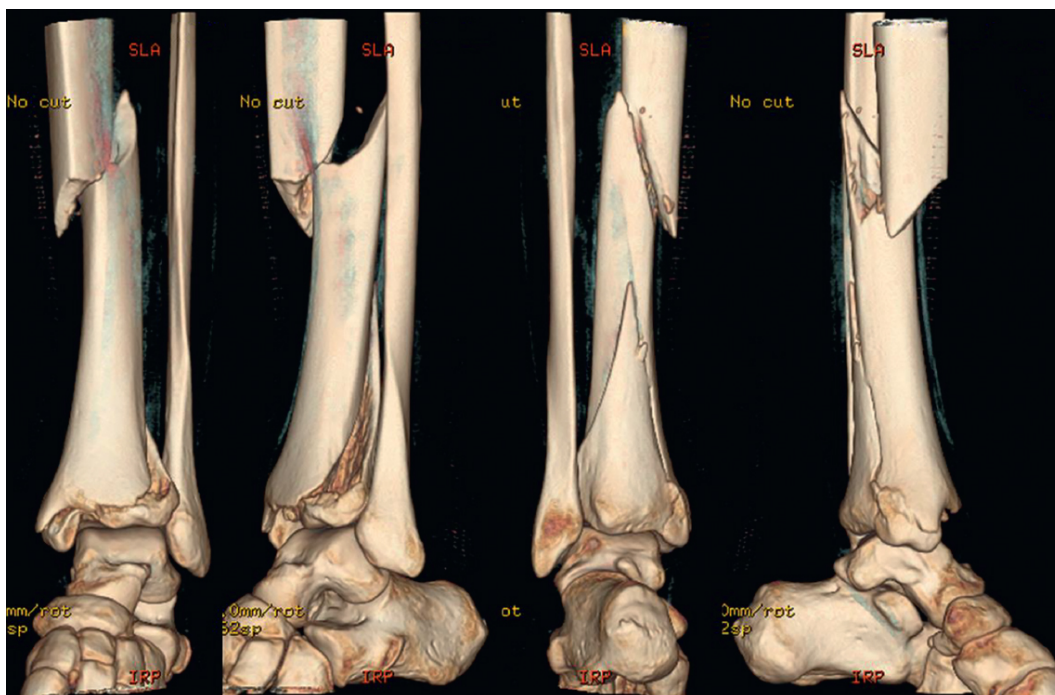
Despite a distal tibial fracture component, careful assessment of this CT scan demonstrated insight for the proper clamp vectors for reduction and fixation with distal lag screws and intramedullary nail stabilization.
